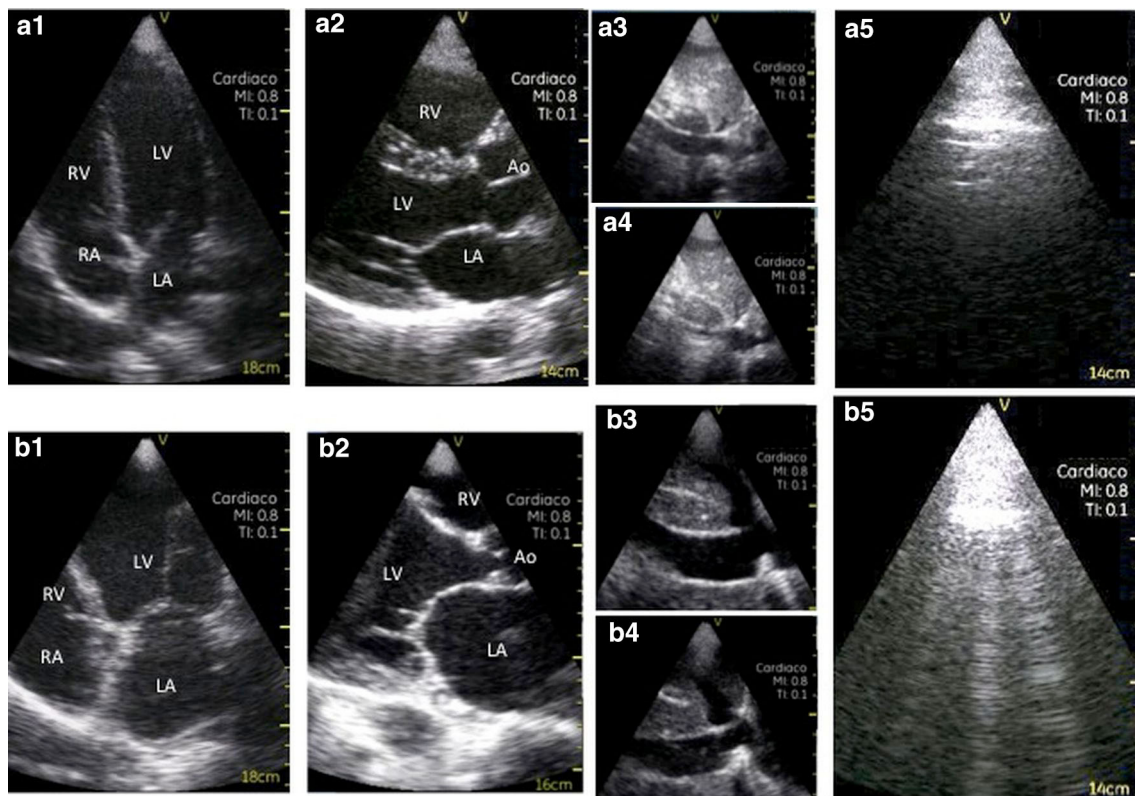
Example of a normal subjects ('a' panels) and a heart failure patient (HF) ('b' panels); scans have been obtained with pocket size ultrasound device. Notice in normal subject preserved dimensions of left atrium and ventricle (a1, a2), collapsibility of IVC during
